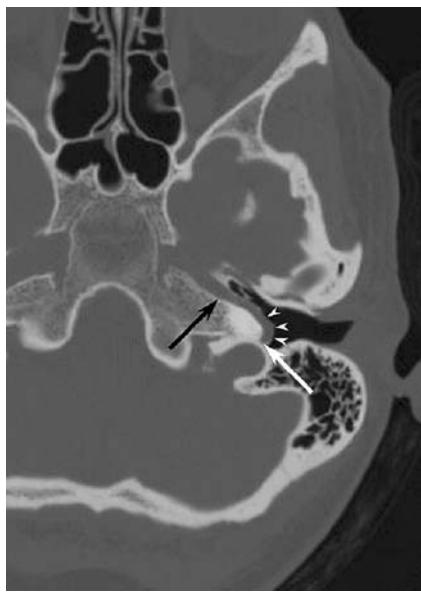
Aberrant internal carotid artery. Axial bone-window CT demonstrates an abnormal course of the petrous ICA. The artery enters the middle ear through the inferior tympanic canniliculus (white arrow), just anterolateral to the jugular bulb. It courses through the mesotympanum (arrowheads) to recombine with a diminutive petrous internal carotid artery (black arrow) that then continues on its normal course
